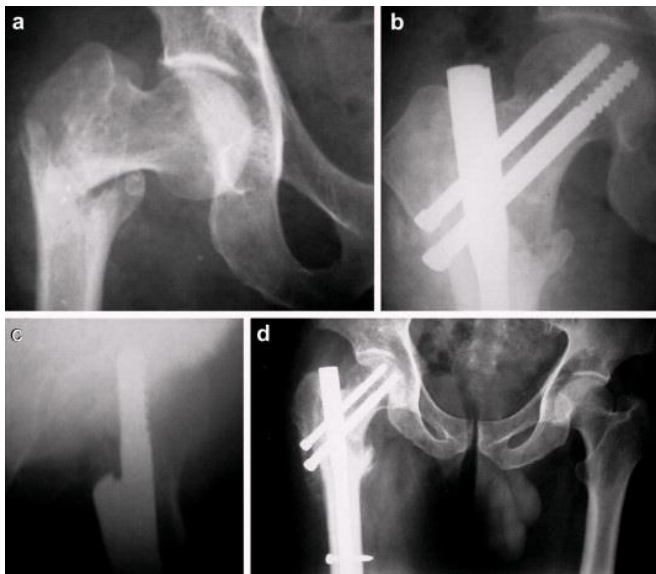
A 41 year old female with Right sided stable intertrochanteric fracture treated with PFN. a) Preoperative image. B & C) immediate postoperative anteroposterior and lateral radiograph. d) Anteroposterior radiograph showing union at 6 weeks follow up.
